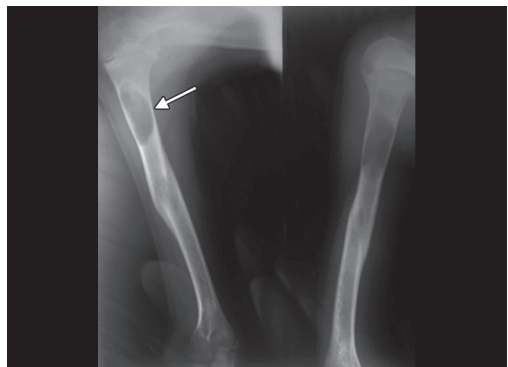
X-ray: Simple bone cyst (proximal humerus)
